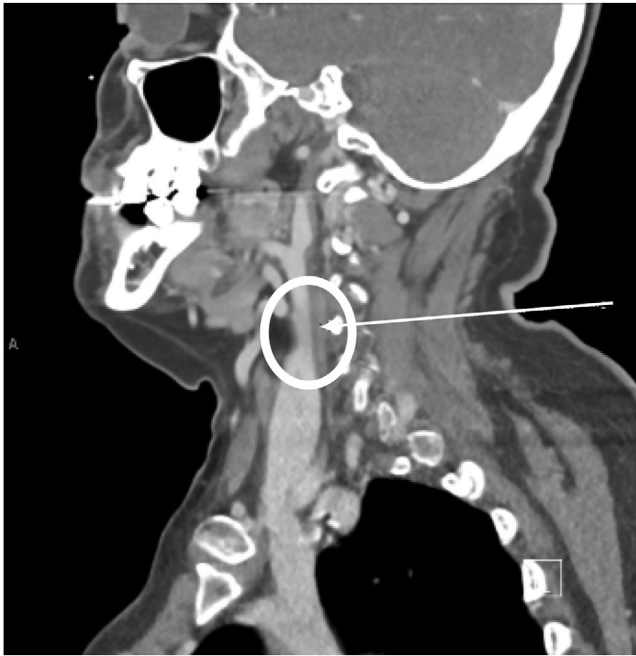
TIPIC syndrome on the sagittal plane of the CTA neck. Arrow identifies evidence of circumferential thickening of the distal left common carotid artery. Abbreviations: CTA, computed tomography angiography; TIPIC, transient perivascular inflammation of the carotid artery.
